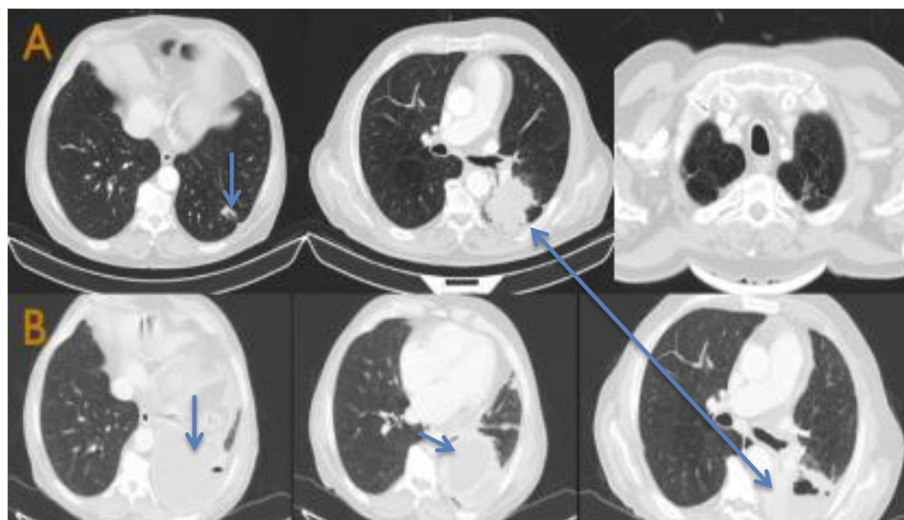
A CT scan at the start of the lung mass study in case 1. A non-specific nodule of 1 cm in diameter is seen in the left lung base (first image) and a mass in the apicoposterior segment of the left upper lobe measuring 6.47×5.07 cm (central image). Fig. 1B CT scan on admission in case 1. Two cavitated masses are seen: one in LUL (already known), and a new one in LLL with a liquid component.
